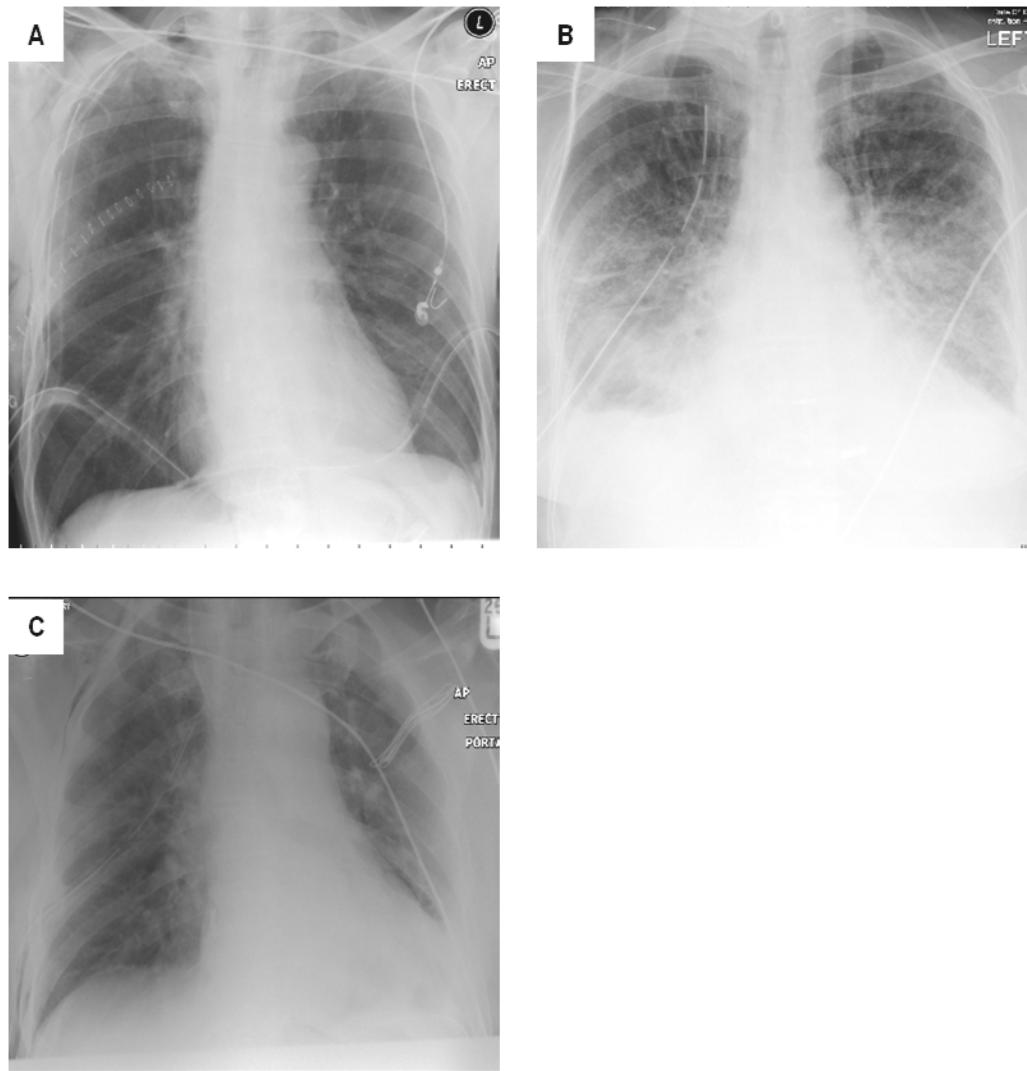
Examples of frontal chest radiographs taken in patients post oesophagectomy. Panel A shows appearances with clear lung fields and bilateral chest drains *in-situ*. Panel B shows bilateral pulmonary infiltrates consistent with pulmonary oedema. The cardiac silhouette is not enlarged. These appearances are consistent with a possible diagnosis of ALI. Panel C shows bilateral opacities over the lower zones bilaterally. On the left there is evidence of collapse and consolidation of the lower lobe with a possible pleural effusion. On the right side there is evidence of the gastric pull through and atelectasis within the lower zone.
